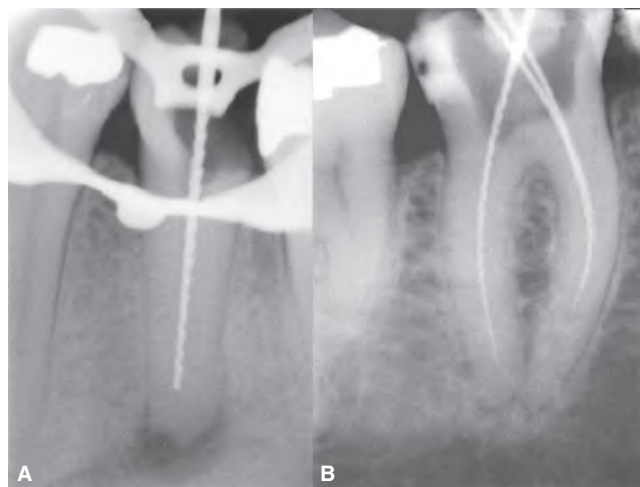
8 A. endodontic instruments in a mandibular second premolar tooth with a radiolucent periapical pathosis; B. mandibular molar with slight widening of the apical periodontal ligament space of the distal root. These images were made using the DentX Eva (CMOS) system (AFP/DentX, Elmsford, NY, USA).
